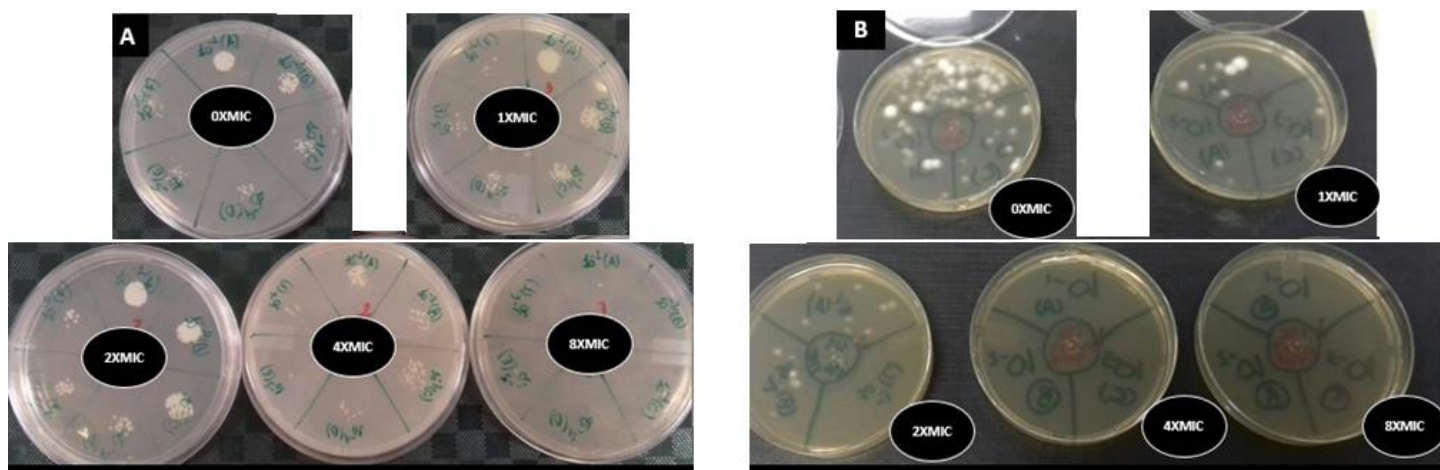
Time kill experiment images of the growth of *C. tropicalis* (CT 72A; A) and *T. mentagrophytes* (TME 16; B) treated *in vitro* with compound 2j at different concentrations (0xMIC – drug free control, 1xMIC, 2xMIC, 4xMIC and 8xMIC; MIC = 1.56 $\mu\text{g}/\text{mL}$ for CT 72A and MIC = 3.12 $\mu\text{g}/\text{mL}$ for TME 16), in a maximum experiment time of 48 h for yeasts and 96 h for dermatophytes.
